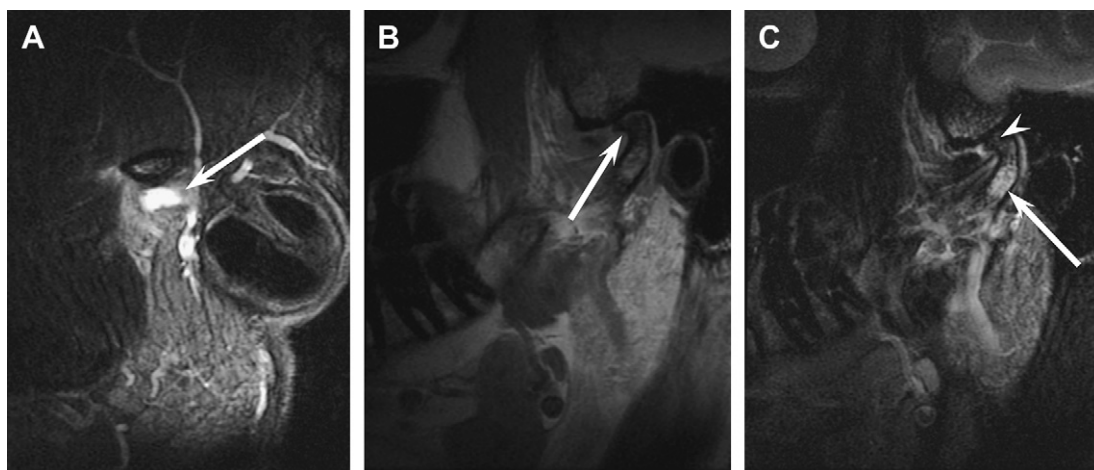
MRI for TMJ osteoarthritis. (A) Sagittal oblique T2-weighted image shows a high-signal collection (arrow), indicating joint effusion. (B) Sagittal oblique T1-weighted image reveals a beak-shaped osteophyte on the anterior aspect of the mandibular condyle (arrow), as well as narrowing of joint space. (C) Sagittal oblique T2-weighted image shows secondary signs of degenerative osteoarthritis, such as subchondral cysts (arrow-head) and bone marrow edema (arrow).
